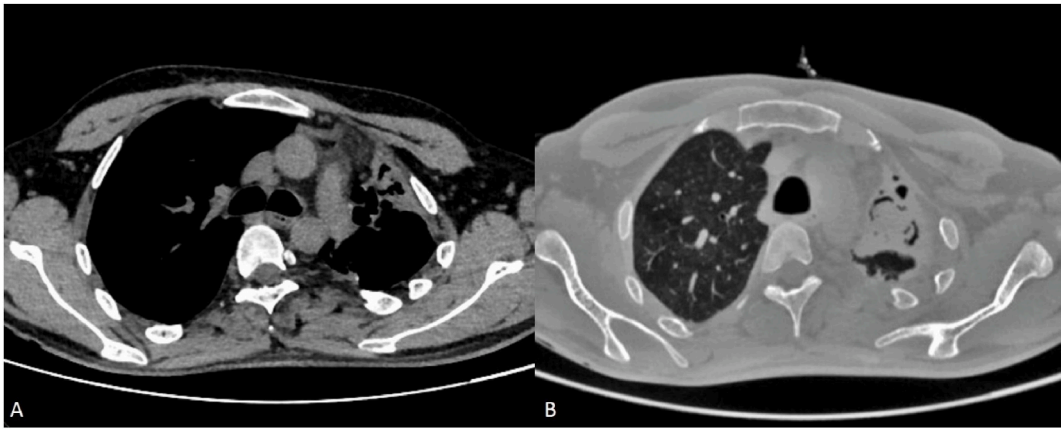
Case 3: CT showing cavitary lung lesion with surrounding fibrotic and bronchiectatic changes in left upper lobe (A) soft tissue window (B) lung window.
